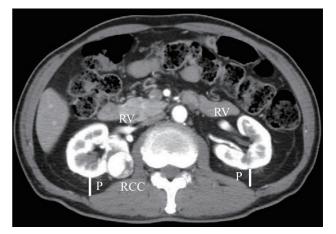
Method of measuring posterior PFT Posterior PFT was measured at the renal vein on preoperative CT.
